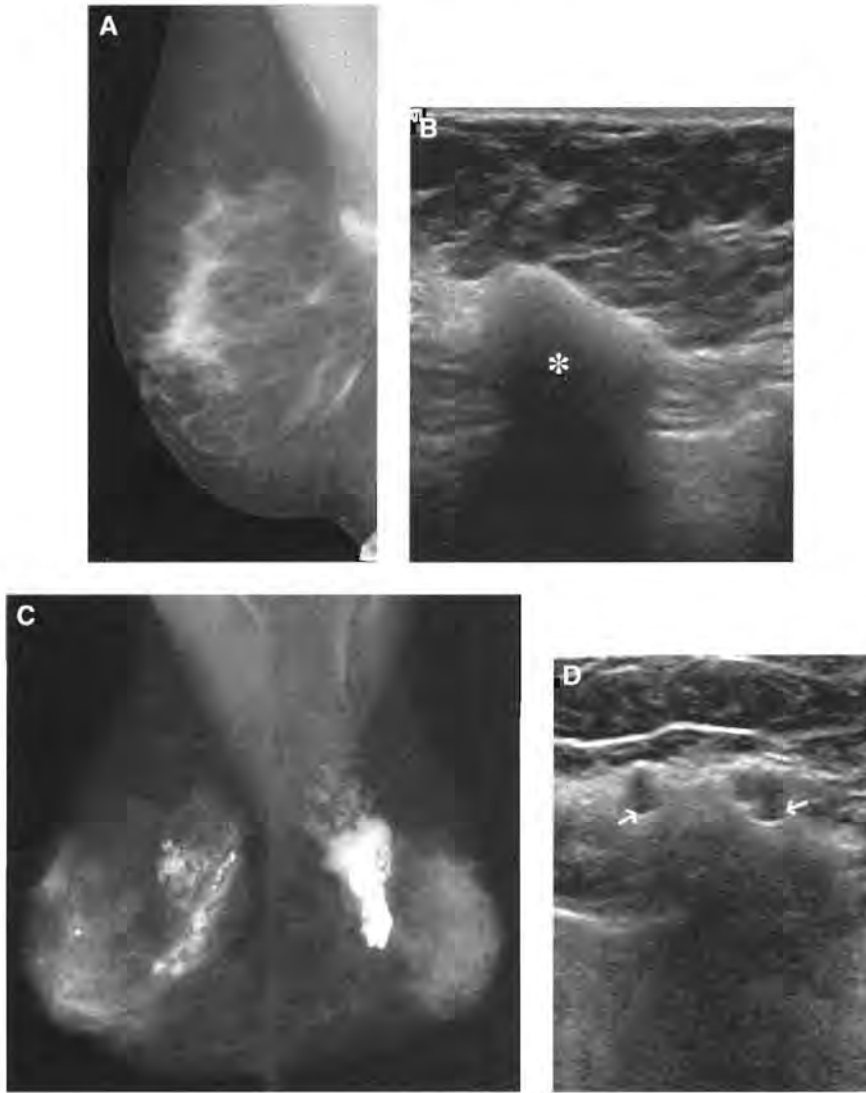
Silicone. (A) Mediolateral oblique view of right breast shows anterior portion of dense lymph node in axilla of patient whose silicone implant had been removed 2 years earlier. (B) Sonogram of lymph node displays signature characteristic of silicone in tissue: "snowstorm" pattern of echogenic noise (*asterisk*) that fades posteriorly. (C) Digital mediolateral oblique mammograms show capsules containing residual silicone. Silicone implants had been removed 2 years earlier. (D) The same pattern of echogenic noise seen in (B) is present in a sonogram of the retained silicone and capsule. The angular hypoechoic nodules (*arrows*) represent silicone granulomas.
